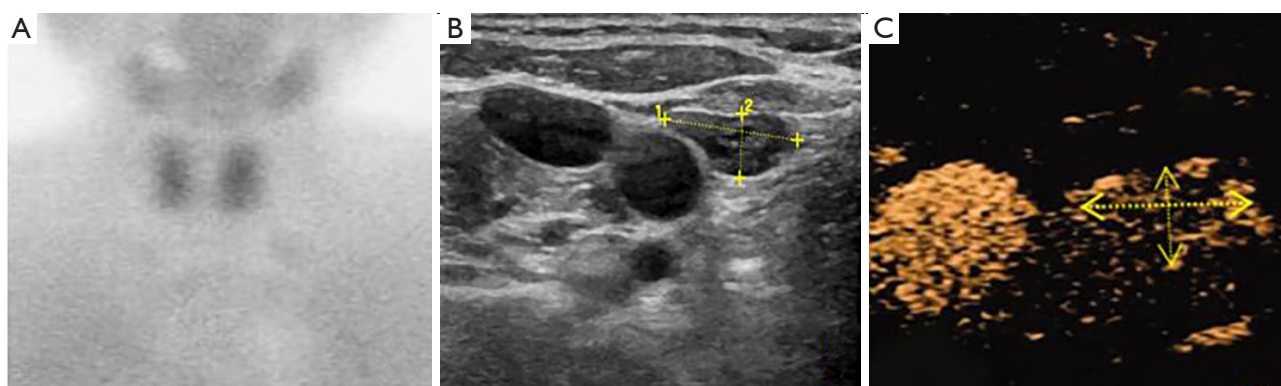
Radiologic findings taken at our hospital of the patient's neck. (A) The ^{99m}Tc sestamibi scan showed no focal radiotracer uptake. (B) The grayscale ultrasound scan showed a hypoechoic nodule (as indicated by the yellow crosses) beside the carotid artery. (C) The CEUS scan showed a uniform hyperenhanced nodule (as indicated by the yellow arrows) beside the carotid artery. CEUS, contrast-enhanced ultrasound.
